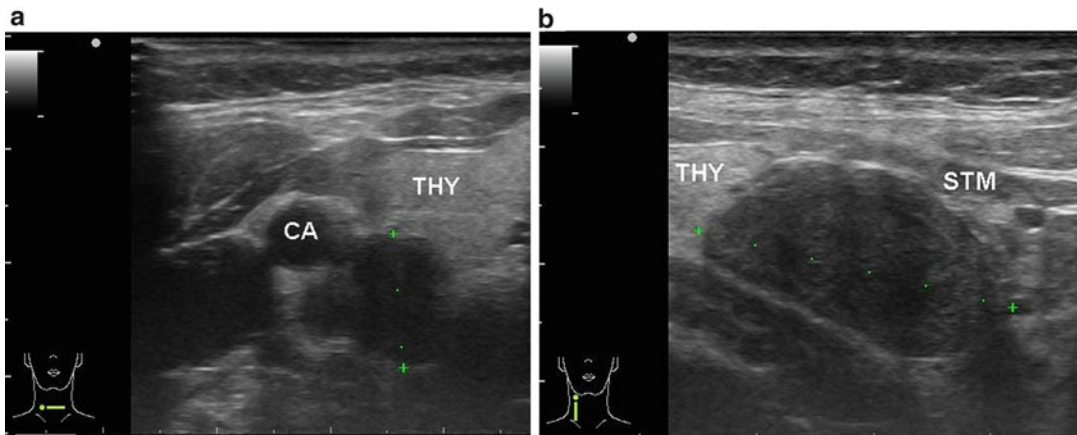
Transverse (a) and longitudinal (b) ultrasonographic views of an abnormal upper parathyroid gland, located on the posteromedial aspect of the thyroid. When
